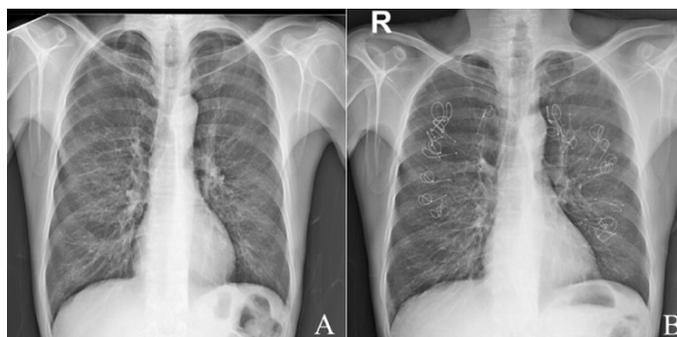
Preoperative (a) and postoperative (b) chest X-Ray images for a patient who underwent bilateral EBCT procedure.
